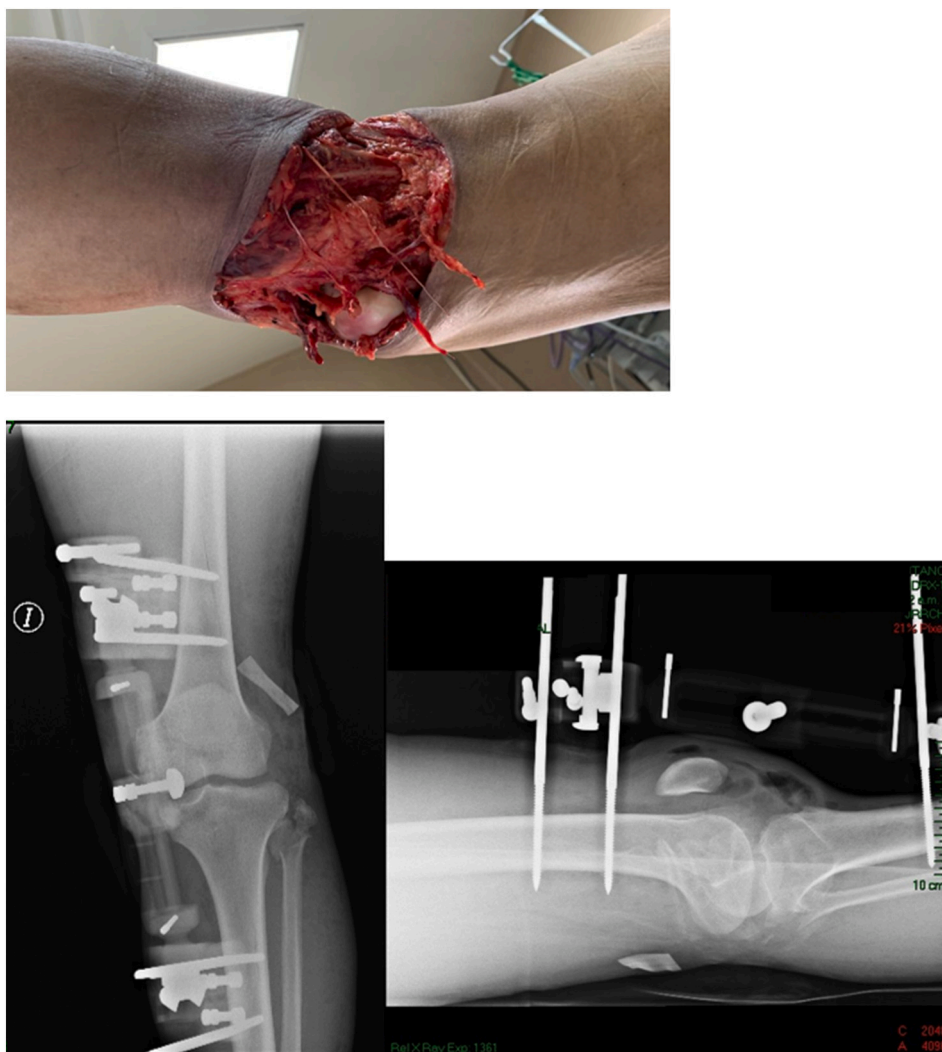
A) OR Findings, B, C) X-Ray Controls after external fixation.
